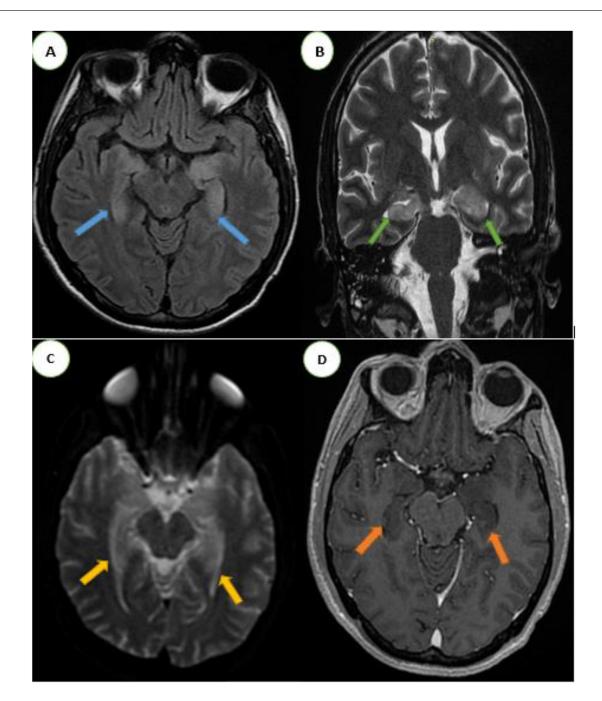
Cerebral MRI: Axial T2 Flair (A), coronal T2 (B), diffusion (C), and axial T1 with injection of Gadolinium (D): Bilateral and symmetrical hippocampal swelling with hypersignal T2 FLAIR () and T2(), hypersignal diffusion (), not enhanced after injection of PDC ().
